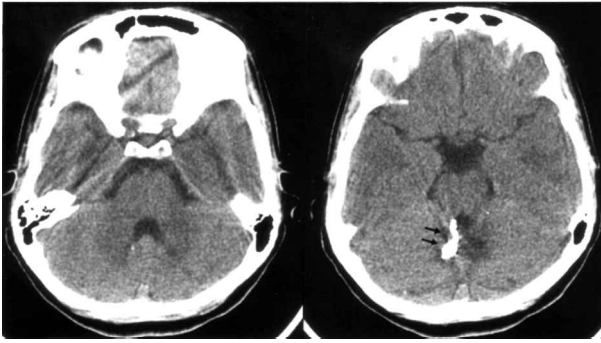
Postendovascular embolization posterior fossa CT scan showed the glue (NBC) obliterating the AVM.
